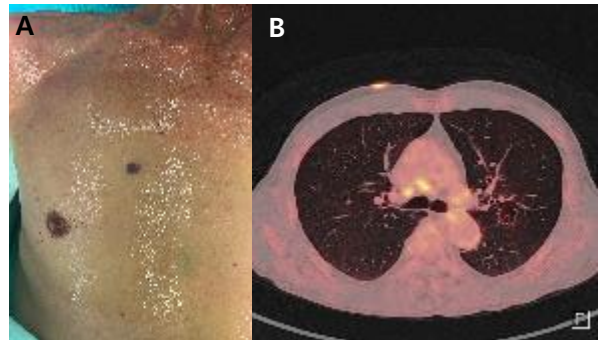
(A) Clinical photograph showing a well-circumscribed, blackish nodule on the right chest wall (B) Positron emission tomography-CT demonstrating increased fluorodeoxyglucose uptake (maximum standardized uptake volume, 6.9)
